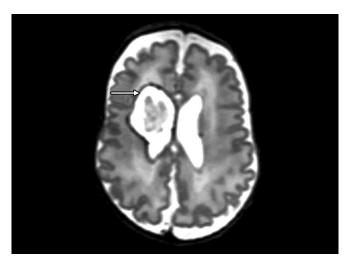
T2 weighted MRI scan demonstrating a right-sided resolving PVHI (arrow), which has evolved into a porencephalic cyst that has merged with the lateral ventricle
